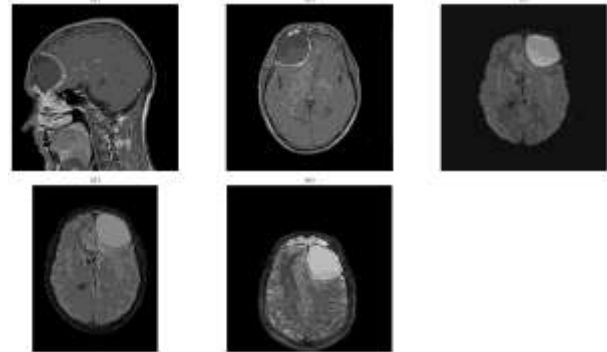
Multisequence MRI of a Right Frontal Epidural Abscess in a Patient with Complicated Acute Rhinosinusitis: (a) Sagittal post-contrast T1-weighted MRI demonstrates a peripherally enhancing, extra-axial collection in the right frontal epidural space with mass effect and midline shift. (b) Axial post-contrast T1-weighted image shows smooth rim enhancement and adjacent dural thickening without parenchymal invasion. (c) Axial diffusion-weighted imaging (DWI) reveals intense central diffusion restriction, indicating viscous purulent material. (d) Axial FLAIR image displays perilesional hyperintensity and cortical sulcal effacement due to surrounding vasogenic edema. (e) Axial T2-weighted image depicts a hyperintense abscess core with a hypointense capsule, consistent with mature abscess morphology and inflammatory mass effect.
